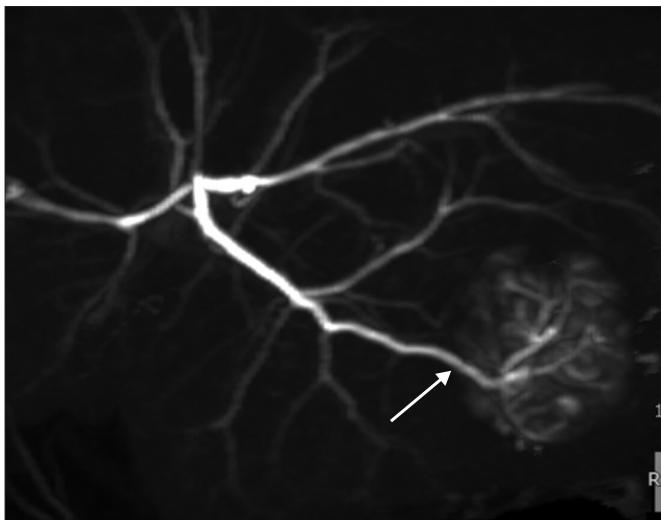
Structure of tumor feeder to a peripheral nodule apart from proximal Glisson sheath. A main tumor feeder was connected with intra-nodular tumor vessels on slab maximum intensity projection image of trans-arterial multi-detector computed tomography (arrow). The diameter of intra-nodular tumor vessel was larger than that of the tumor feeder.
